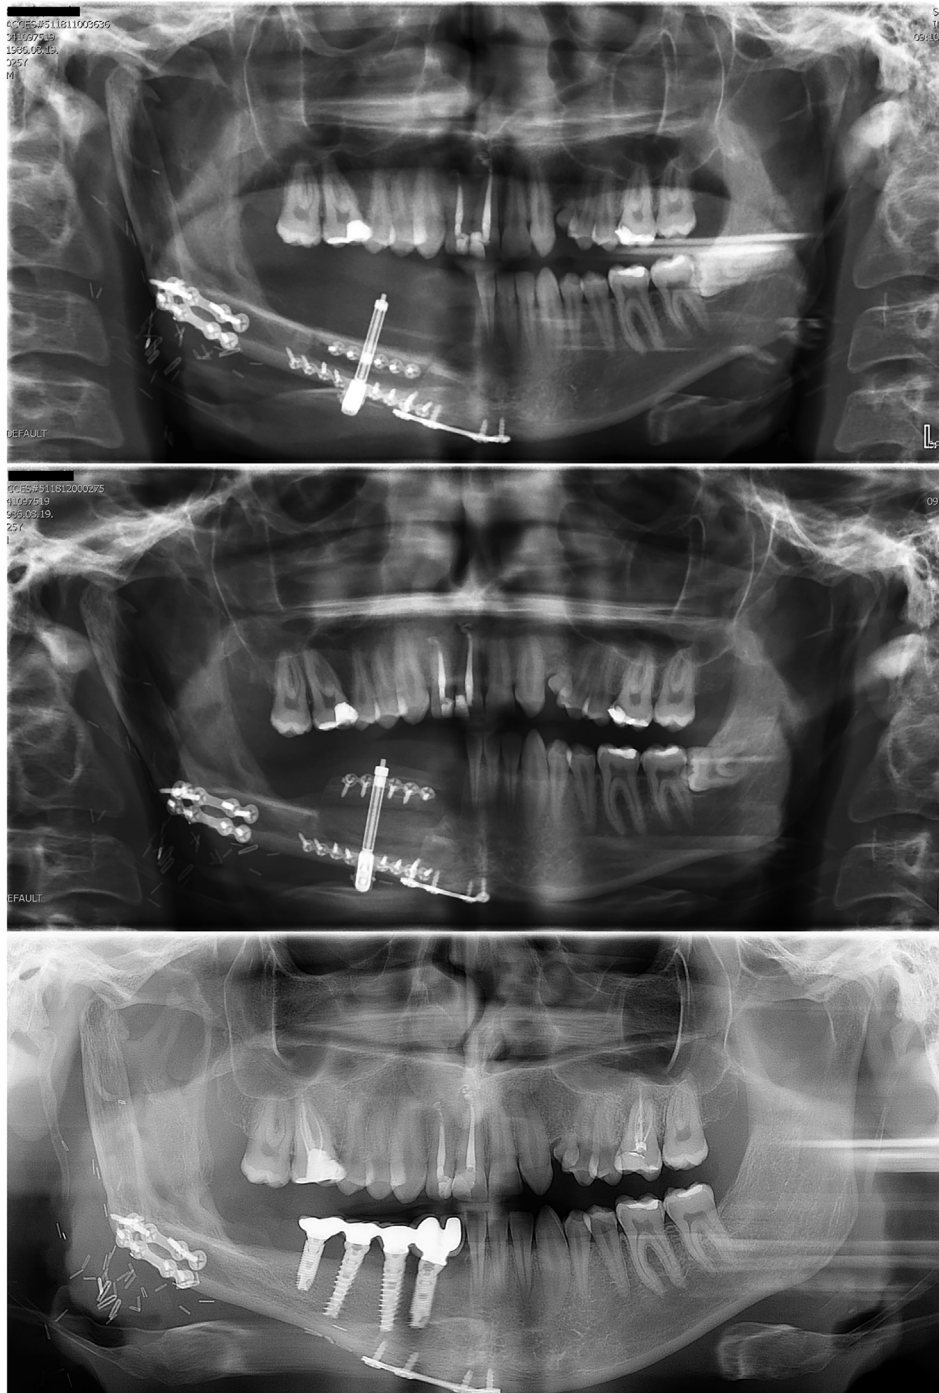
Case 2. Panoramic x-ray images. Top: at the beginning of osteodistraction; Middle: at the end of osteodistraction; Bottom: at the 1-year follow-up.
